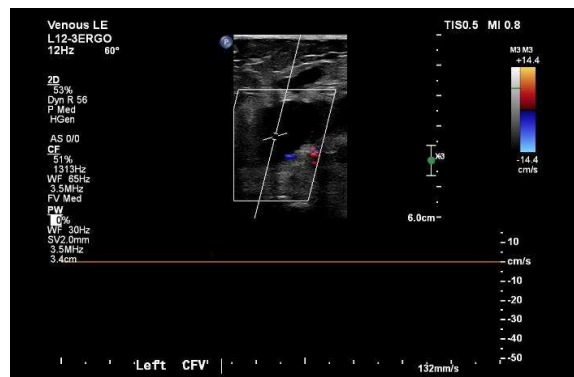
Initial doppler US of the left common femoral vein showing almost a completely thrombosed vein.
